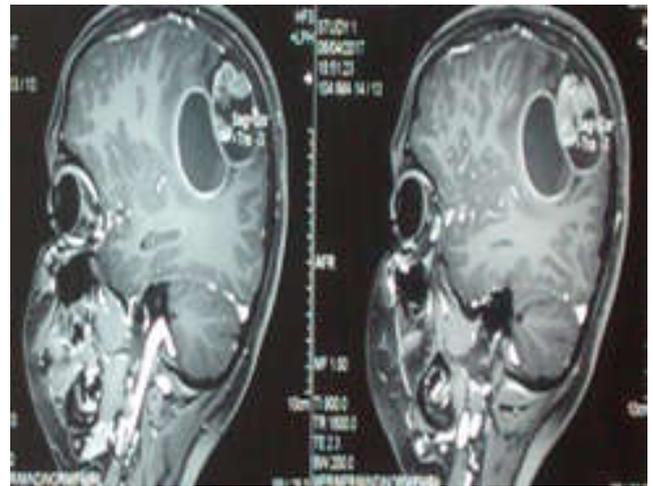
T1 weighted MRI with contrast showing a heterointense lesion in left frontoparietal region with hemorrhagic/necrotic component with irregular peripheral enhancement
